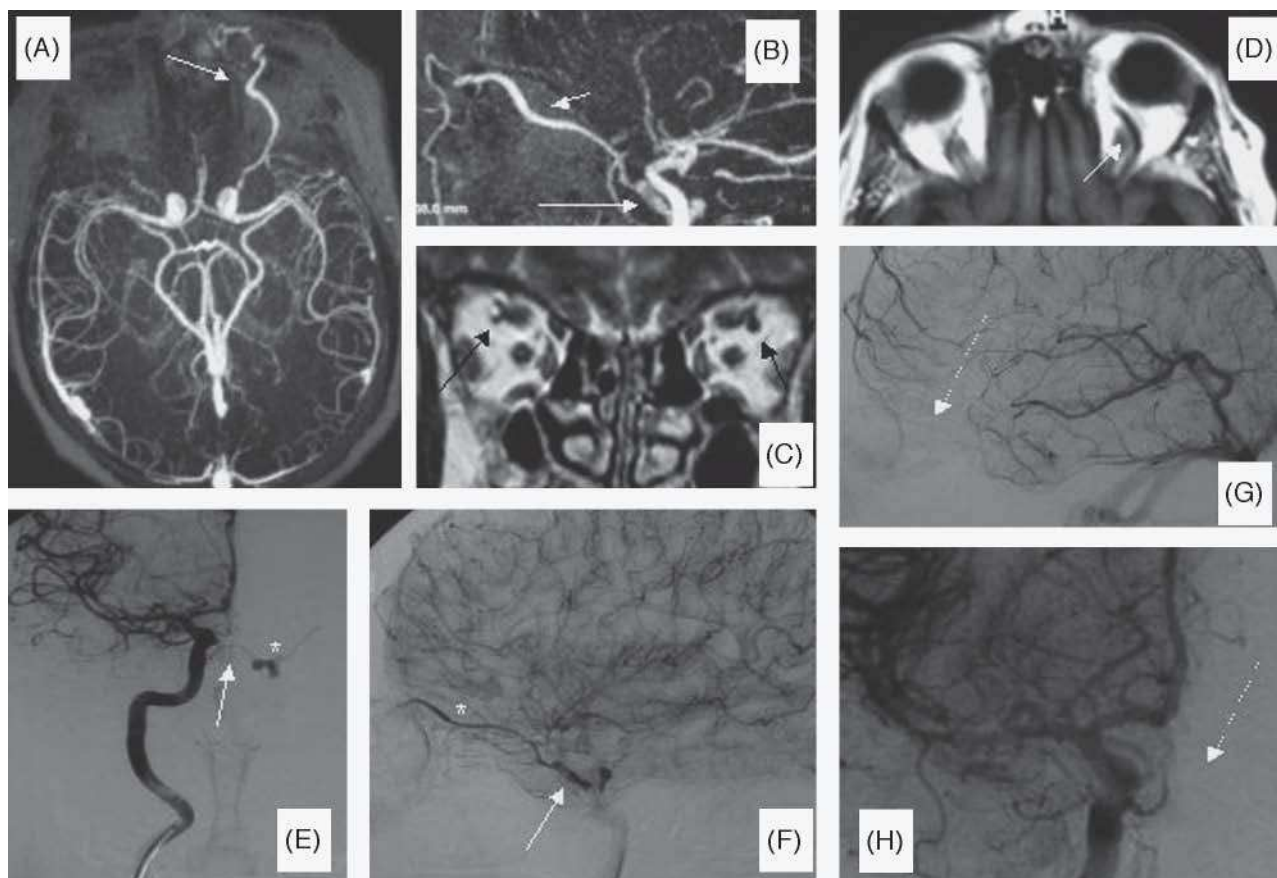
A: Contrast-enhanced magnetic resonance angiography, axial plane. B: sagittal plane. Early filling of the left cavernous sinus and the superior ophthalmic vein. C and D: T1-weighted sequences showing asymmetry and enlargement of the left superior ophthalmic vein. Images of the right carotid artery obtained by digital subtraction angiography. E: diagnostic image showing afference from the right meningohypophyseal trunk. F and G: lateral projection images of the drainage into the left superior ophthalmic vein. H: resolution of the clinical condition observed in E.
